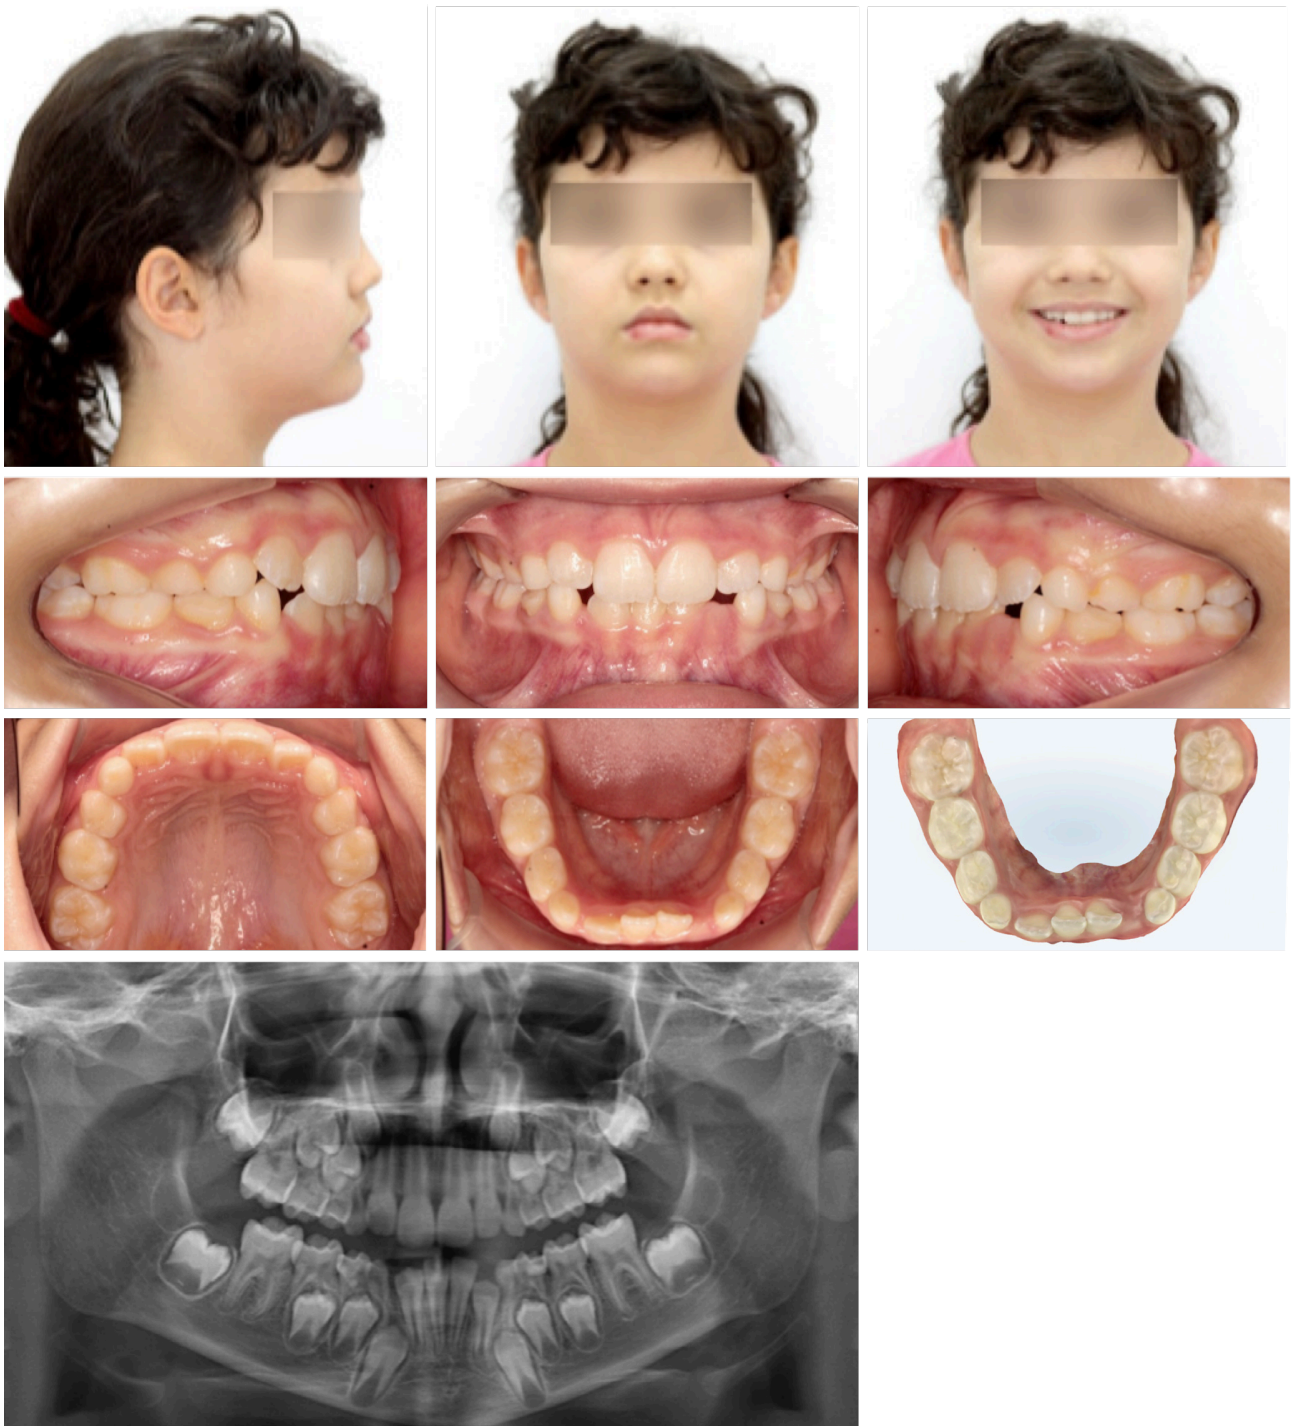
(A-I). Case 4 – 6y 10m: A-H) initial extraoral and intraoral photographs, I) initial panoramic radiograph.
